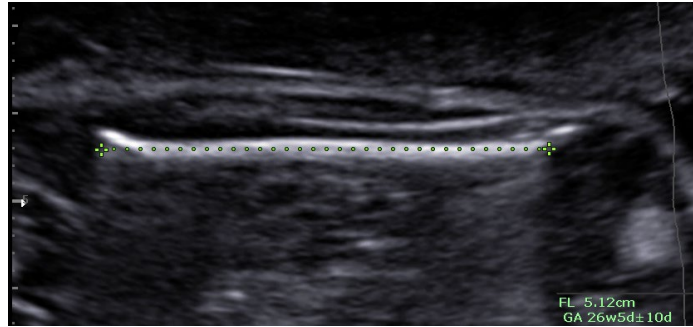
Ultrasound image of fetal femur length (FL). Participant image used with permission.
